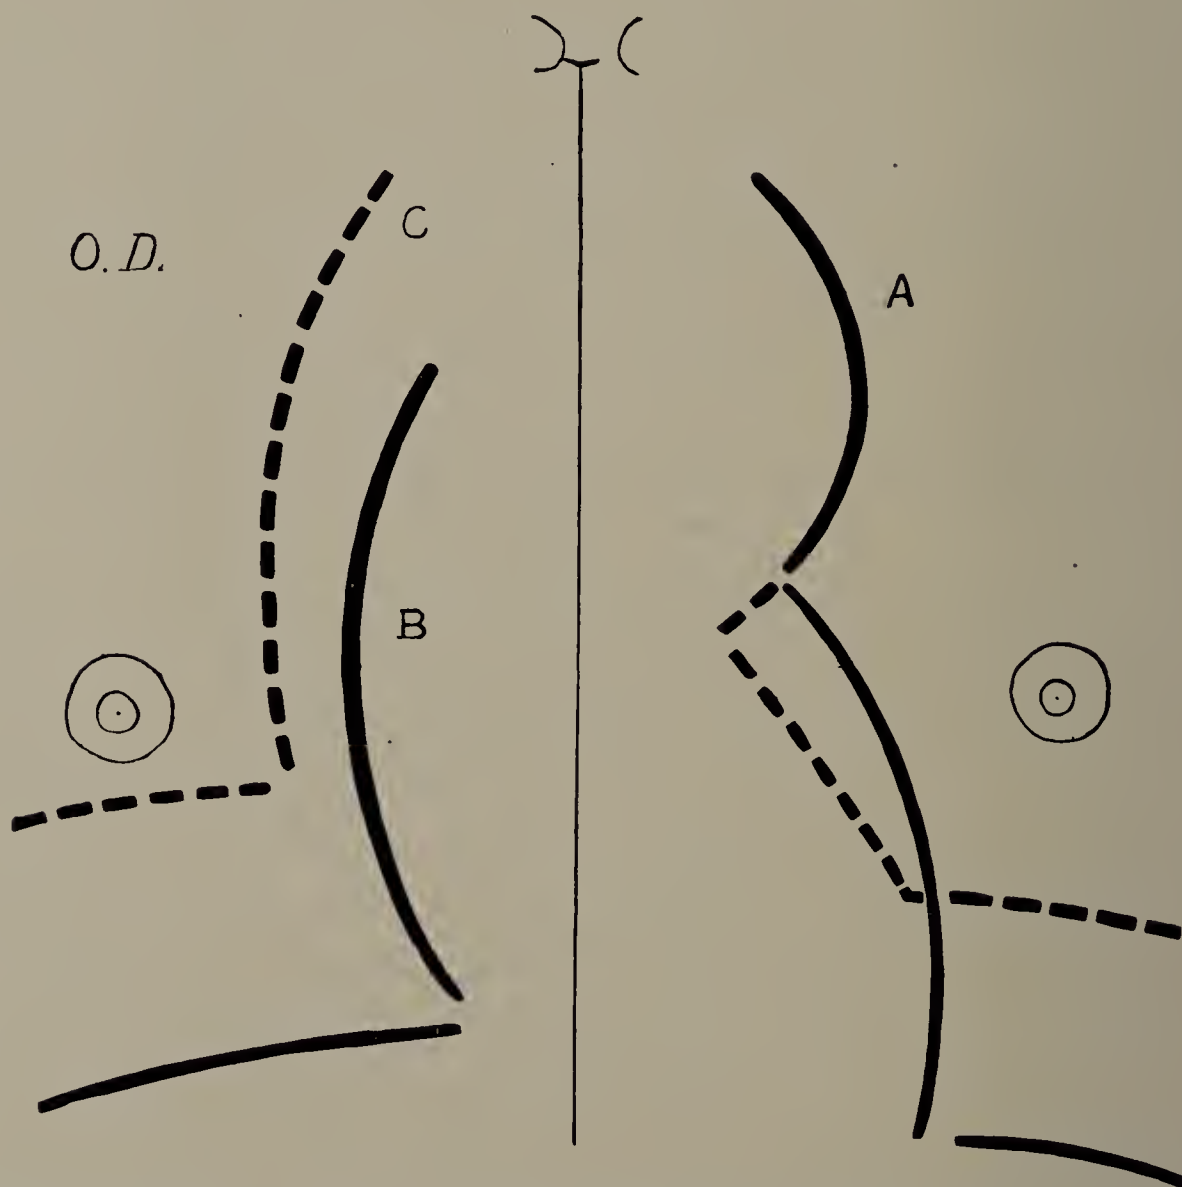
Case XII. O. D. Cut of tracing made with screen on front of chest. X-ray examination shows the outlines of what proved to be an aneurism, and that it was nearer the back than the front of the chest. (Cut one-third life size.)
